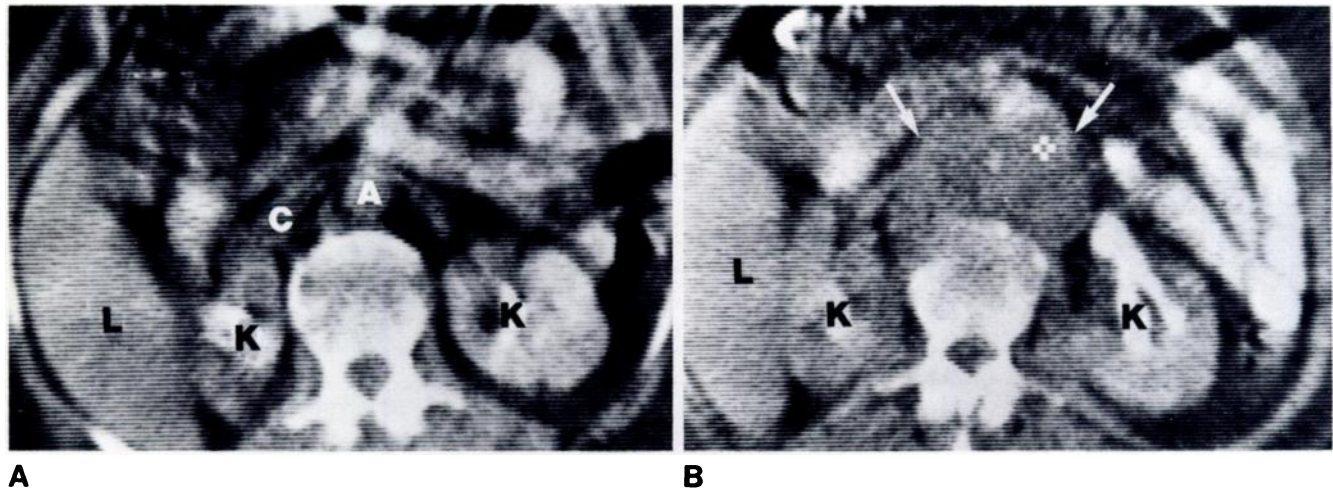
Recurrent stage IIIB cervix carcinoma. A, Baseline CT scan through liver (L) and kidneys (K). Normal aorta (A) and inferior vena cava (C). B, Follow-up scan 9 months later. Extensive retroperitoneal lymph node metastases (arrows) obliterate borders of aorta and inferior vena cava.
